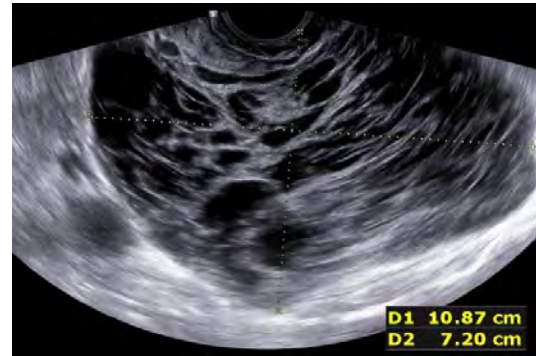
Prospective study 2 Conventional ultrasound scanning Leiomyosarcoma detected preoperatively. US Score 22/25
